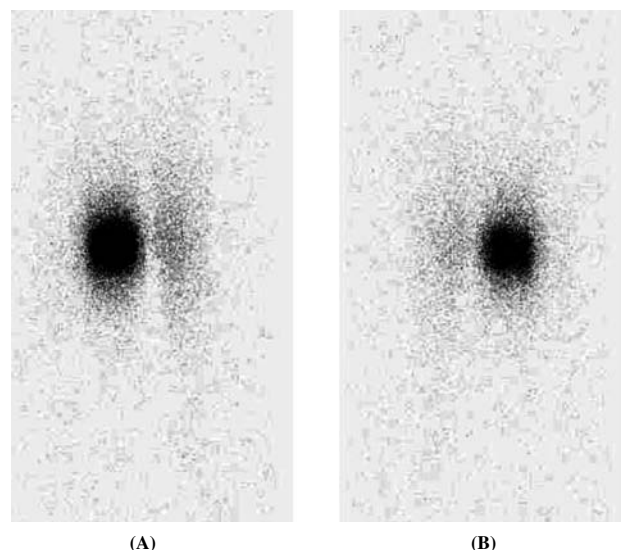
Whole-body scintigraphic images of a patient injected with 5 mCi (185 MBq) of ^{177}Lu -HA (particle size: 1-10 μ) in the knee joint 1 month post-administration.
